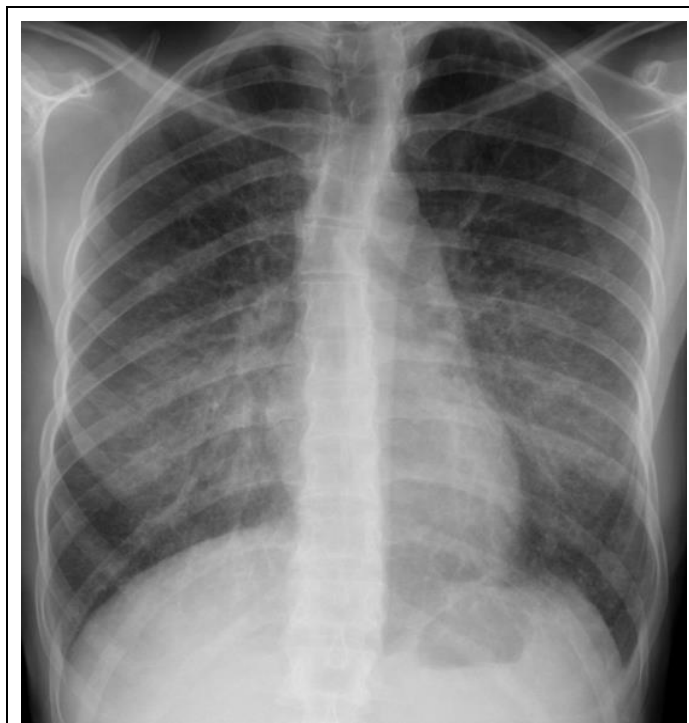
Chest radiograph showing an increase in the pulmonary reticulum.
